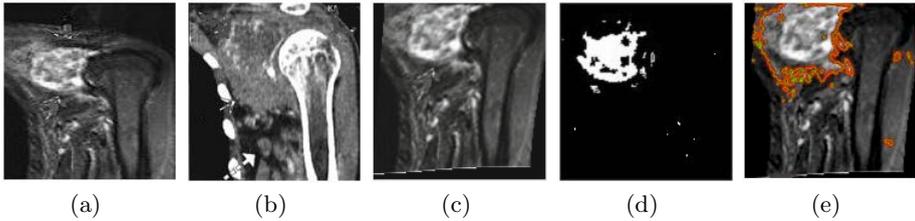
(a) T1 weighted MR image of the left shoulder, (b) CT image for lower leg, (c) registered image (d) initial region of the tumor region (PFCM classification result), (e) Final segmented tumor region
